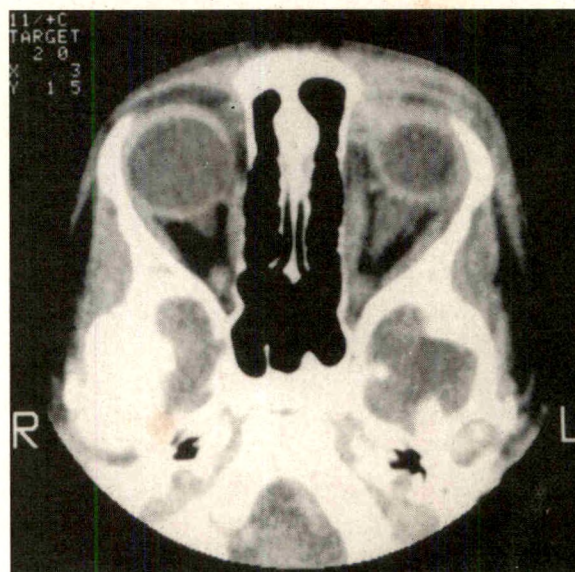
(Linberg and Mayle). Axial computed tomography showing enlarged extraocular muscles, scleral enhancement, and irregular infiltrates in the fat of the left orbit.
